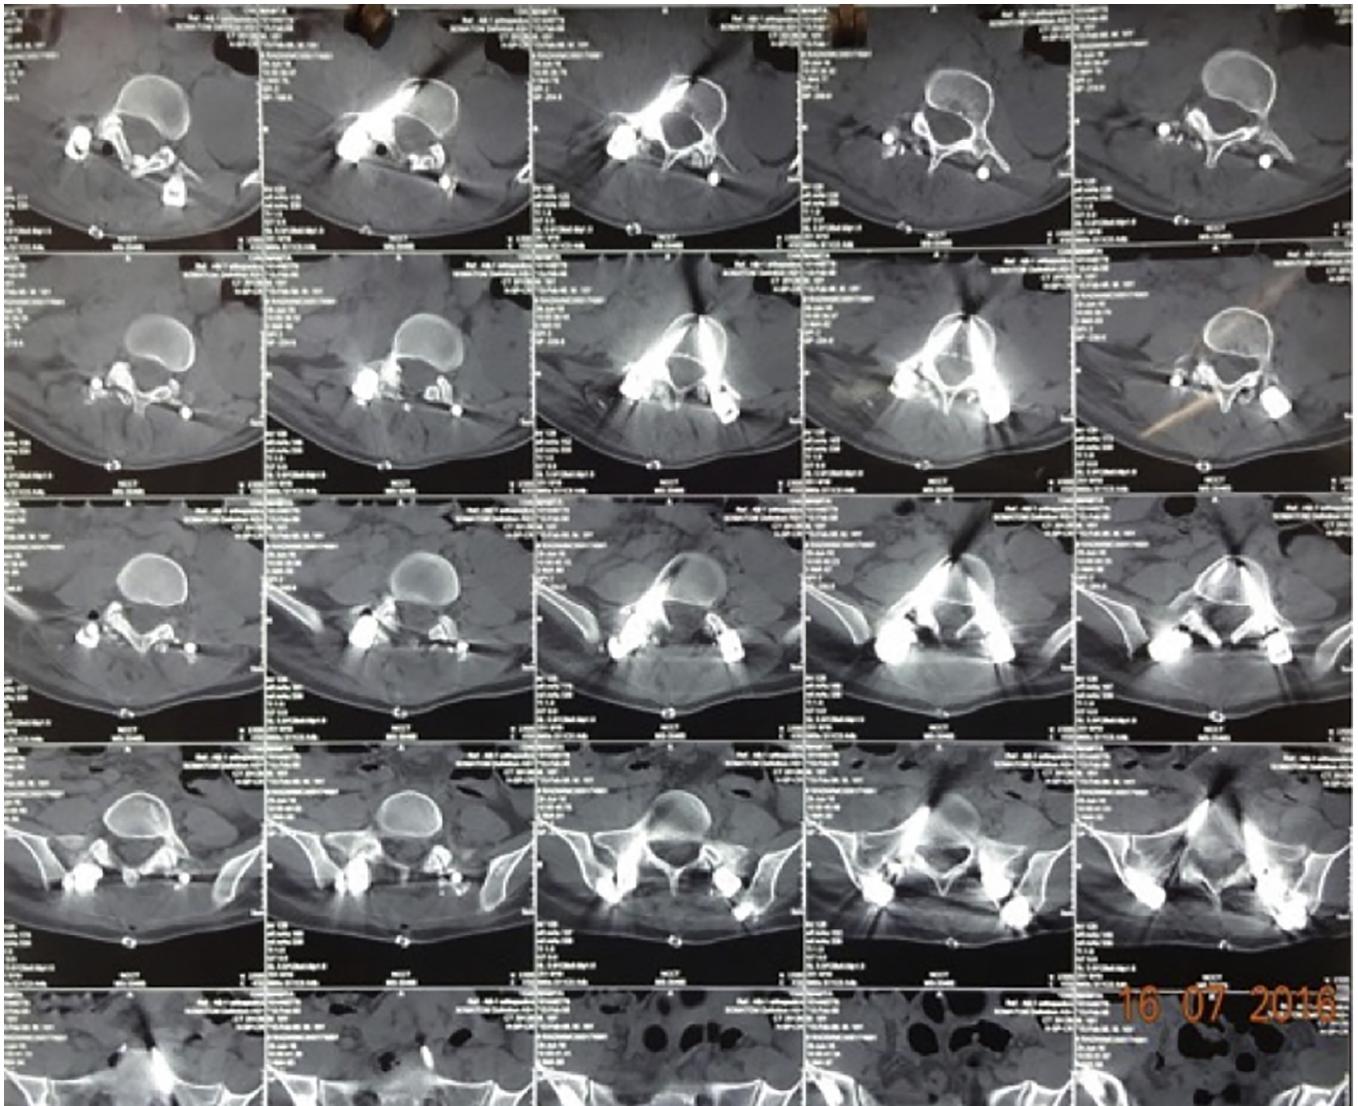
Axial CT scan showing perfect placement of all screws in the patient, operated on with the help of 3D printing. 3D, three-dimensional; CT, computed tomography.
